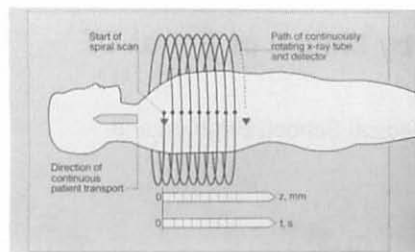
Scanning geometry at Spiral-CT
